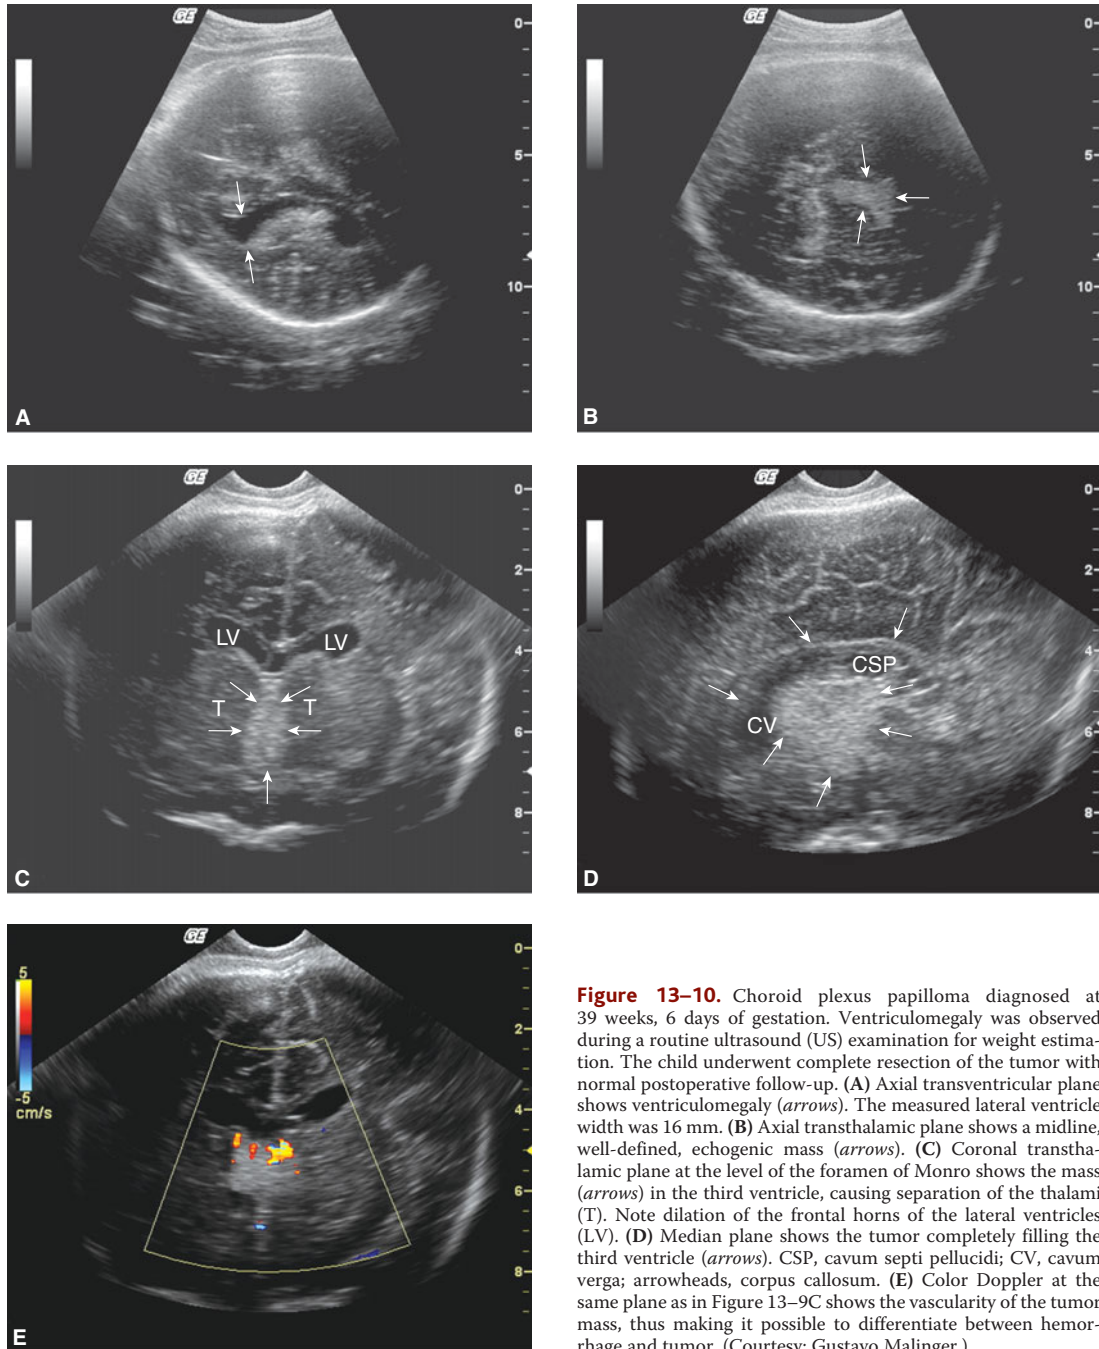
Choroid plexus papilloma diagnosed at 39 weeks, 6 days of gestation. Ventriculomegaly was observed during a routine ultrasound (US) examination for weight estimation. The child underwent complete resection of the tumor with normal postoperative follow-up. (A) Axial transventricular plane shows ventriculomegaly (arrows). The measured lateral ventricle width was 16 mm. (B) Axial transthalamic plane shows a midline, well-defined, echogenic mass (arrows). (C) Coronal transthalamic plane at the level of the foramen of Monro shows the mass (arrows) in the third ventricle, causing separation of the thalami (T). Note dilation of the frontal horns of the lateral ventricles (LV). (D) Median plane shows the tumor completely filling the third ventricle (arrows). CSP, cavum septi pellucidum; CV, cavum verga; arrowheads, corpus callosum. (E) Color Doppler at the same plane as in Figure 13-9C shows the vascularity of the tumor mass, thus making it possible to differentiate between hemorrhage and tumor. (Courtesy: Gustavo Malinger.)
